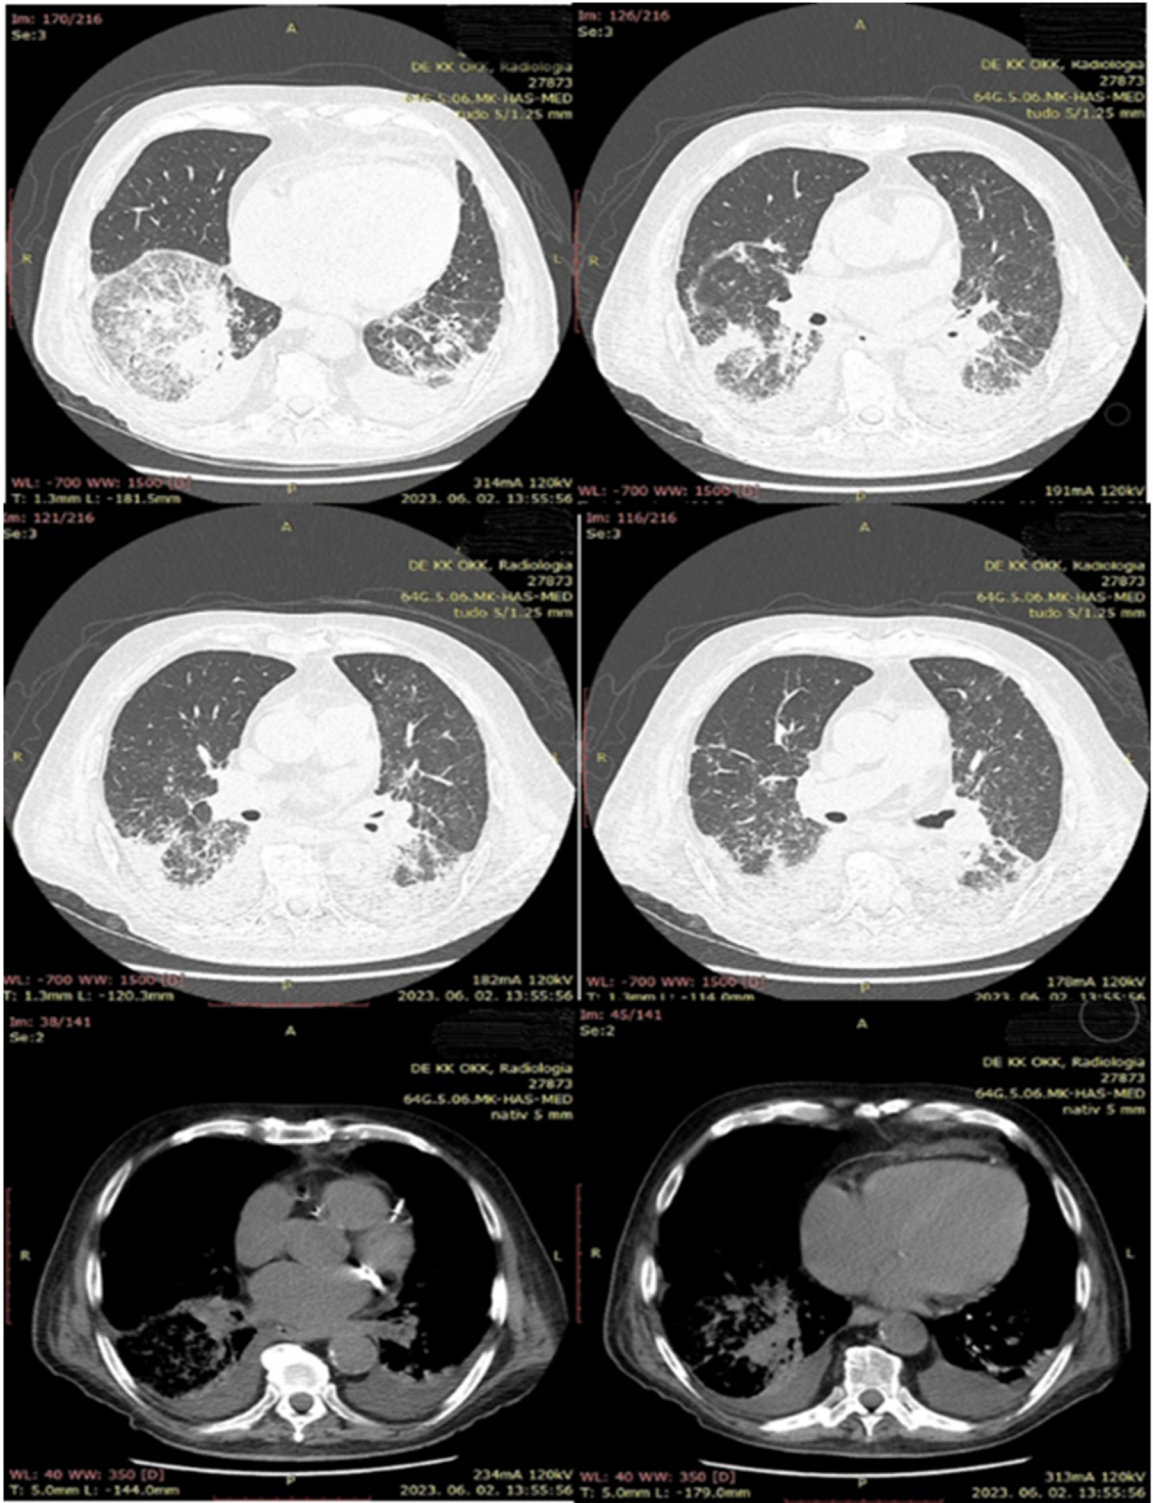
Stenotrophomonas maltophilia* infection in the lung. Axial chest CT scan: bilateral pleural effusion, ground-glass opacity in the right lower lobe, pericardial effusion.
